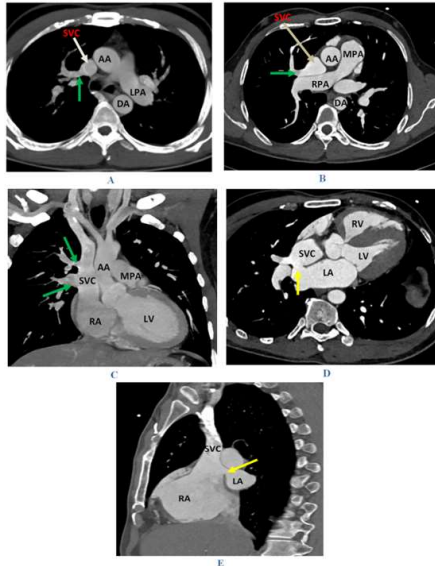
CT cardiac findings showing
